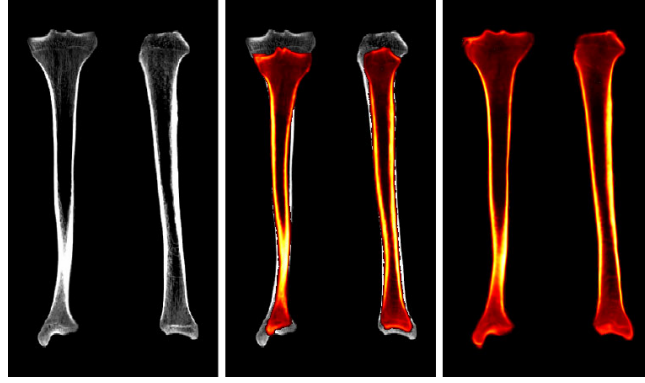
Image registration. CT slice of the left human tibia, chosen as a reference bone; overlay of the rigid registration; overlay of the non-rigid registration matching the reference.
